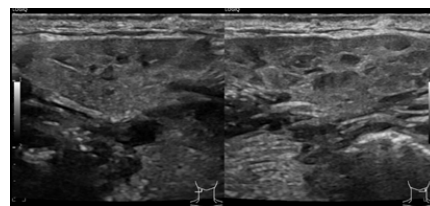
Ultrasound of the submandibular salivary glands showing enlargement and marked parenchymal heterogeneity, which can be due to salivary and lacrimal gland involvement in IgG4-RD.
